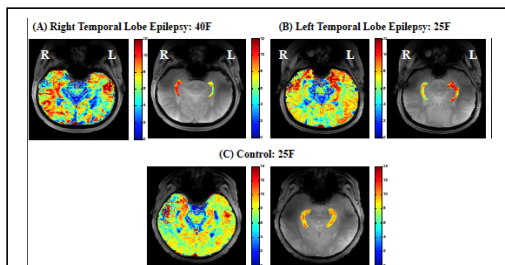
Increased GluCEST signal in hippocampus ipsilateral to seizure onset in subjects with TLE: (A) Subject with MRI negative right TLE with visible increase in GluCEST signal in right hippocampus. (B) Subject with MRI negative left TLE with visible increase in GluCEST signal in left hippocampus most marked in CA1 region. (C) Control subject with symmetric hippocampal GluCEST signal.
